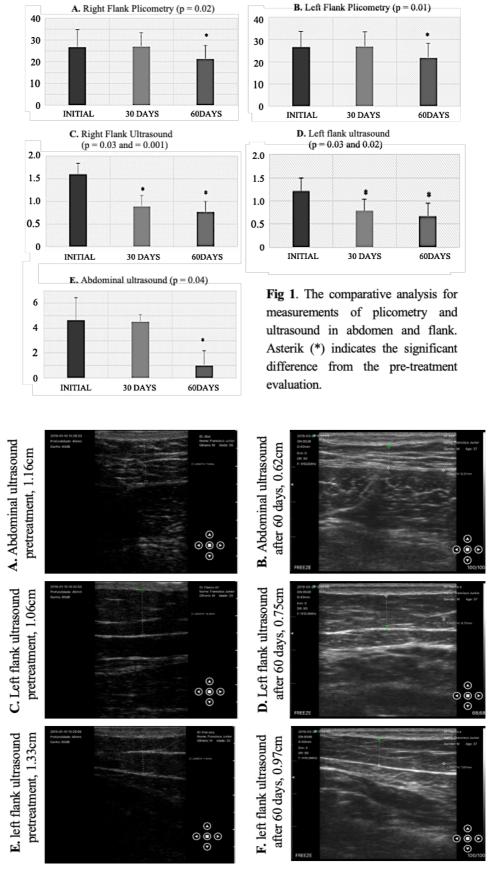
The ultrasound images of the abdomen, right and left flanks for visualization of changes at baseline, 30 and 60 days.
